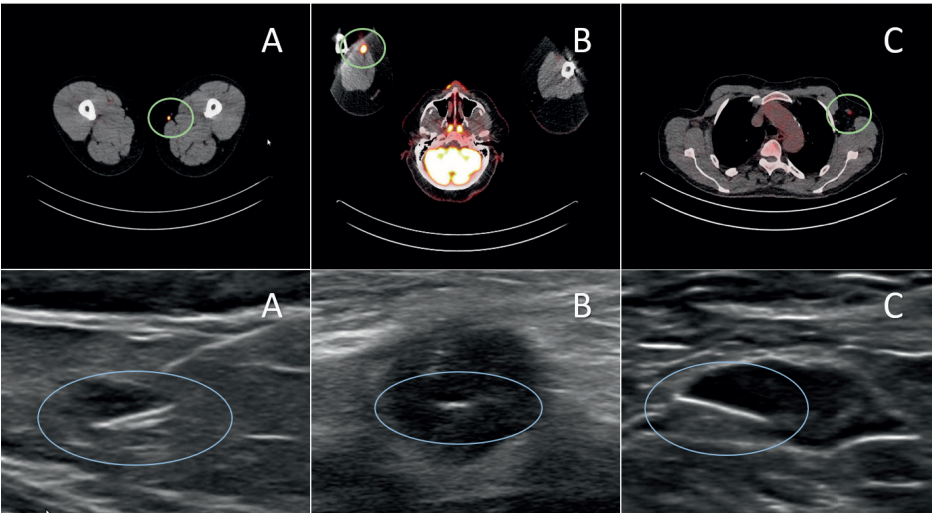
Upper row: 18 F-fluorodeoxyglucose (FDG)-avid lesions on a positron emission tomography/computed tomography (PET/CT). Lower row: Sirius Pintuition markers located in the lesion displayed on ultrasound. A: sub cutaneous melanoma. B: epitheloid sarcoma. C: Lymph node metastasis melanoma
